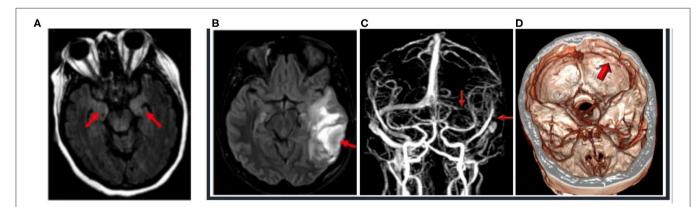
(A) Case 1: 48-year-old, COVID-19-positive female with altered mental status; 3-T MRI axial FLAIR image (red arrows) of hyperintense FLAIR in the medial temporal lobe because of altered mental status and seizures, unable to hold still for scan, with resultant motion artifact. (B–D) Case 2: 29-year-old, COVID-19-positive female who presented with seizures. (B) 1.5-T MRI axial FLAIR (red arrow) of the left temporal lobe with hemorrhagic venous infarction, with the FLAIR hyperintensity consistent with edema and mass effect effacing the left ambient cistern. (C) 1.5-T MRI—time-of-flight MRI—with red arrows noting the absent flow void with venous thrombosis of the left transverse and sigmoid sinus and the left internal jugular vein. (D) CT venogram with the purple arrow demonstrating absent contrast enhancement and thrombosis of the left transverse and sigmoid sinus.
